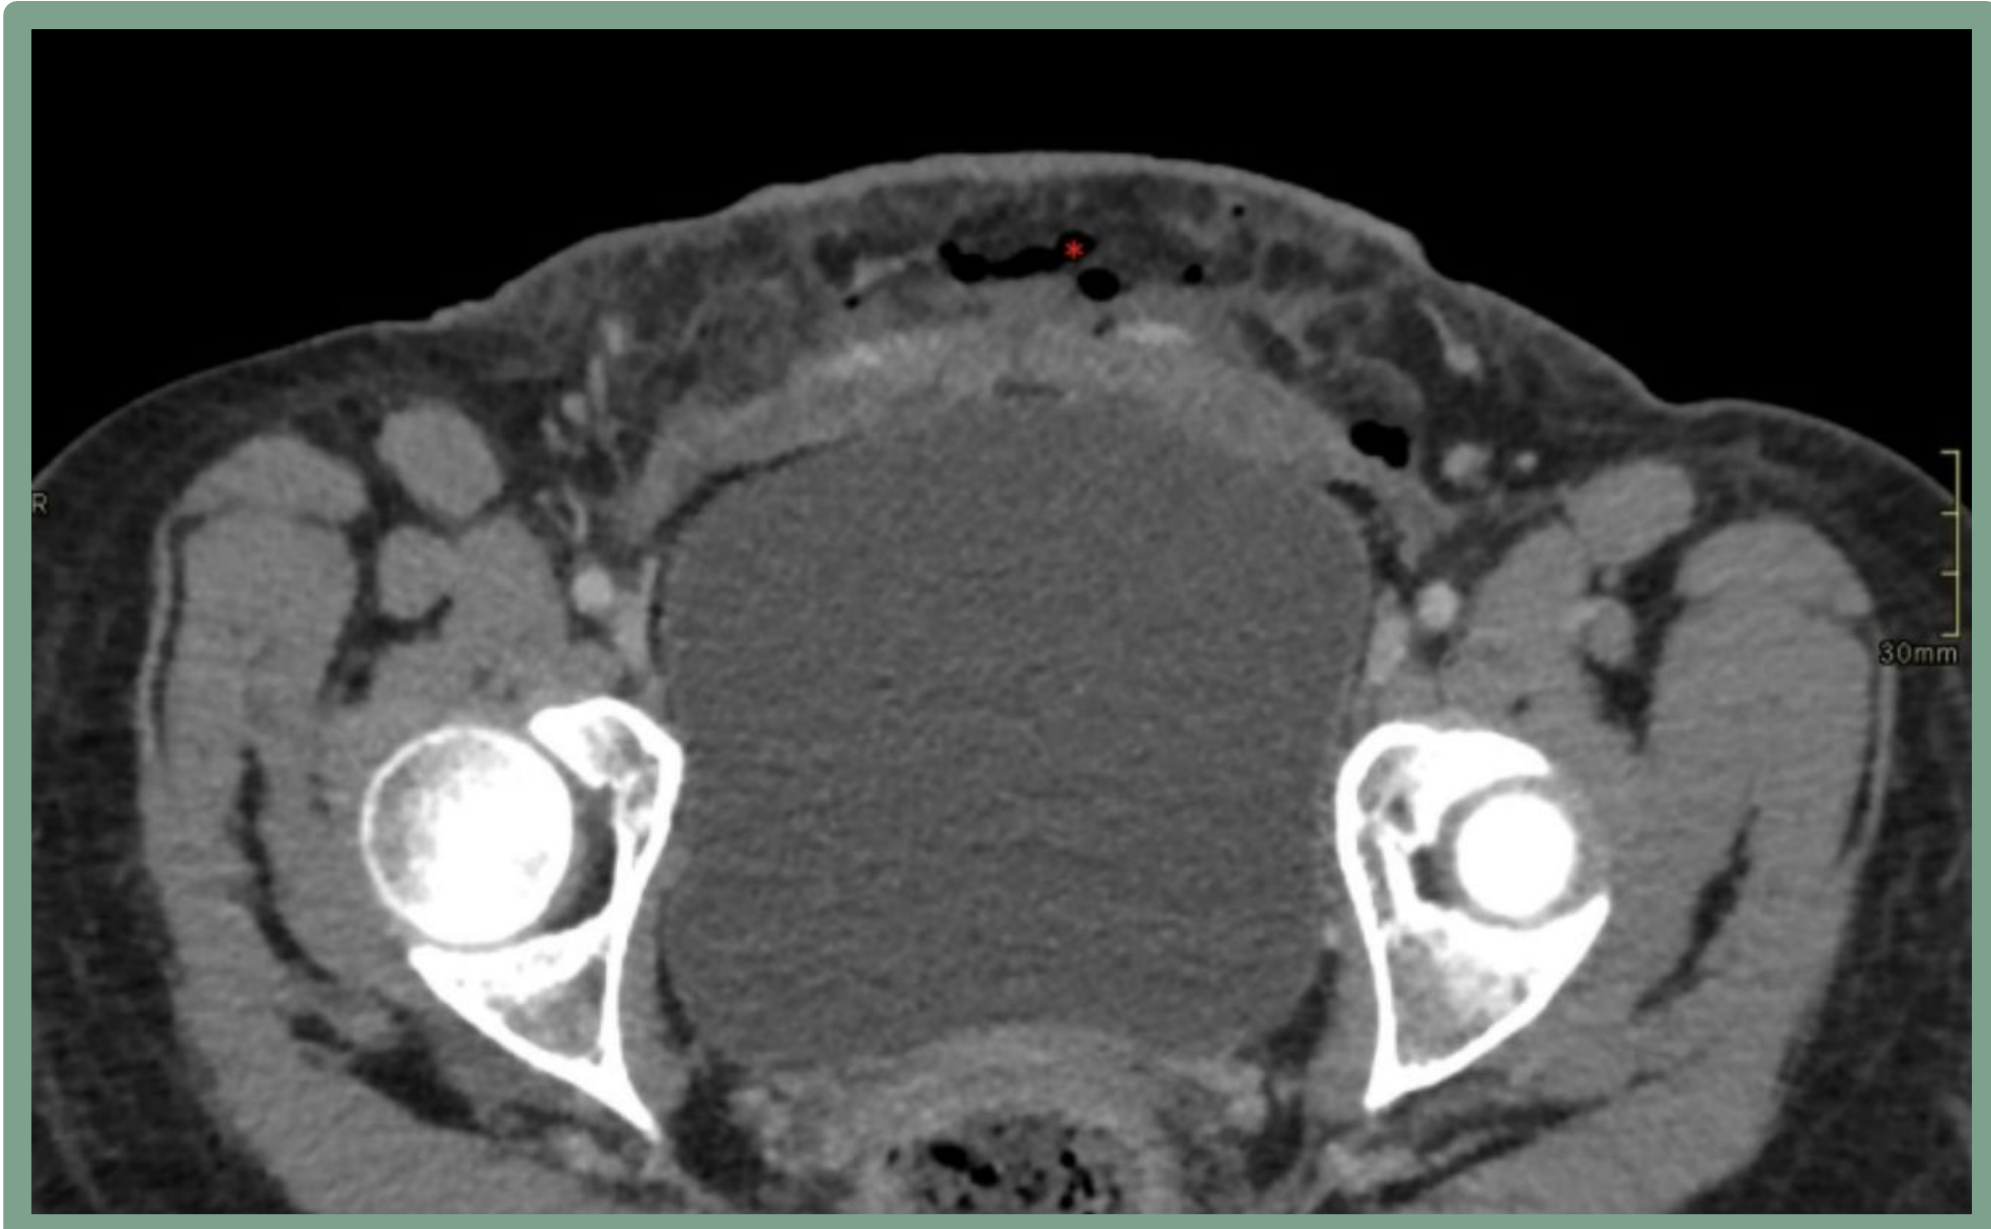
Contrast-enhanced abdominal/pelvic CT at initial hospitalization (November 2025)
